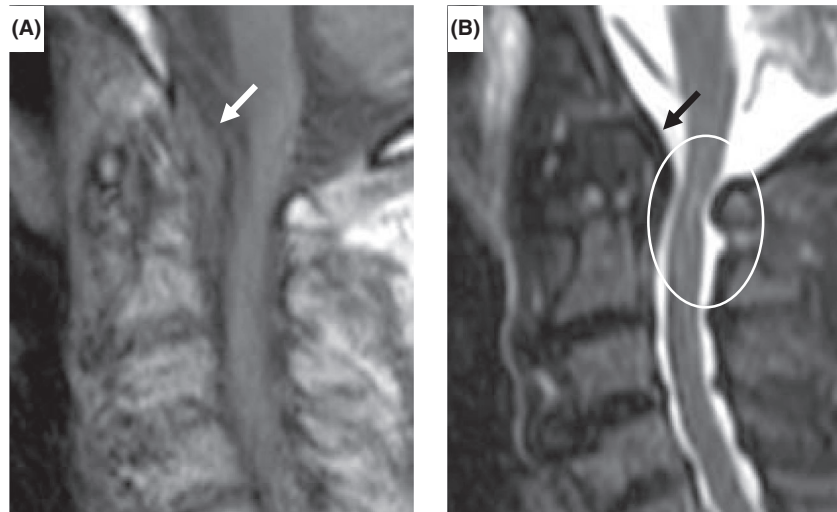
Magnetic resonance imaging (MRI) on admission of an 86-year-old man with retro-odontoid pseudotumor. A, The mass was seen as an iso-intensity area on T1-weighted imaging (white arrow). B, T2-weighted imaging showed cord compression by the low-intensity area (black arrow) posterior to the odontoid process of the axis with high-intensity of the cervical spine at the C1–C2 level (white circle).
